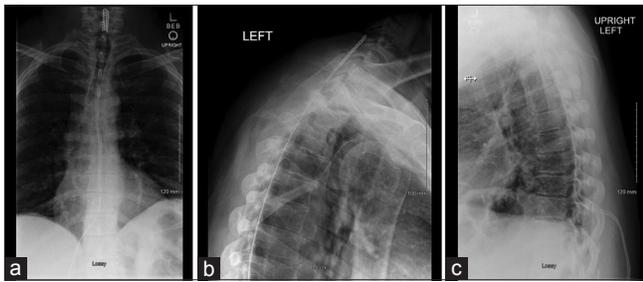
(a) Anterior-posterior and (b) lateral radiographs obtained in clinic demonstrating migration of the epidural paddle to the lower cervical spine. (c) The strain-relief loop has become fully stretched.
